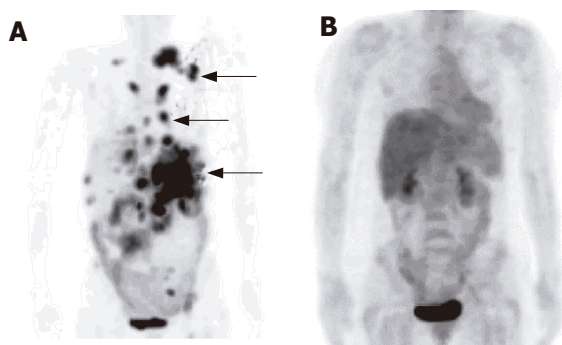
A 61-year-old woman with large cell lymphoma. A: Pre-treatment ^{18}F -FDG PET scan revealed multifocal hypermetabolic activity involving the neck, chest, and abdomen (arrow). The highest SUV_{max} was 20.3 in the left upper abdominal area, corresponding to a positive result of a gastric biopsy; B: Follow-up ^{18}F -FDG PET scan 5 mo later showed no evidence of residual FDG disease.
